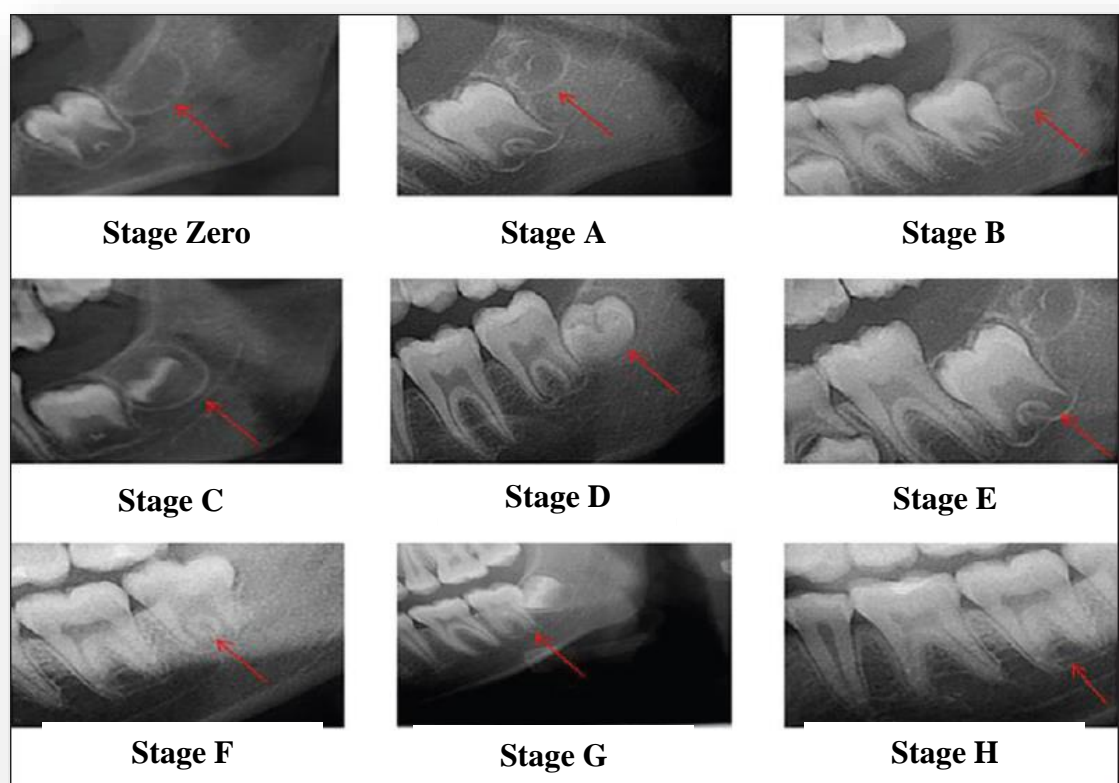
Dental panoramic radiographs of worked example
